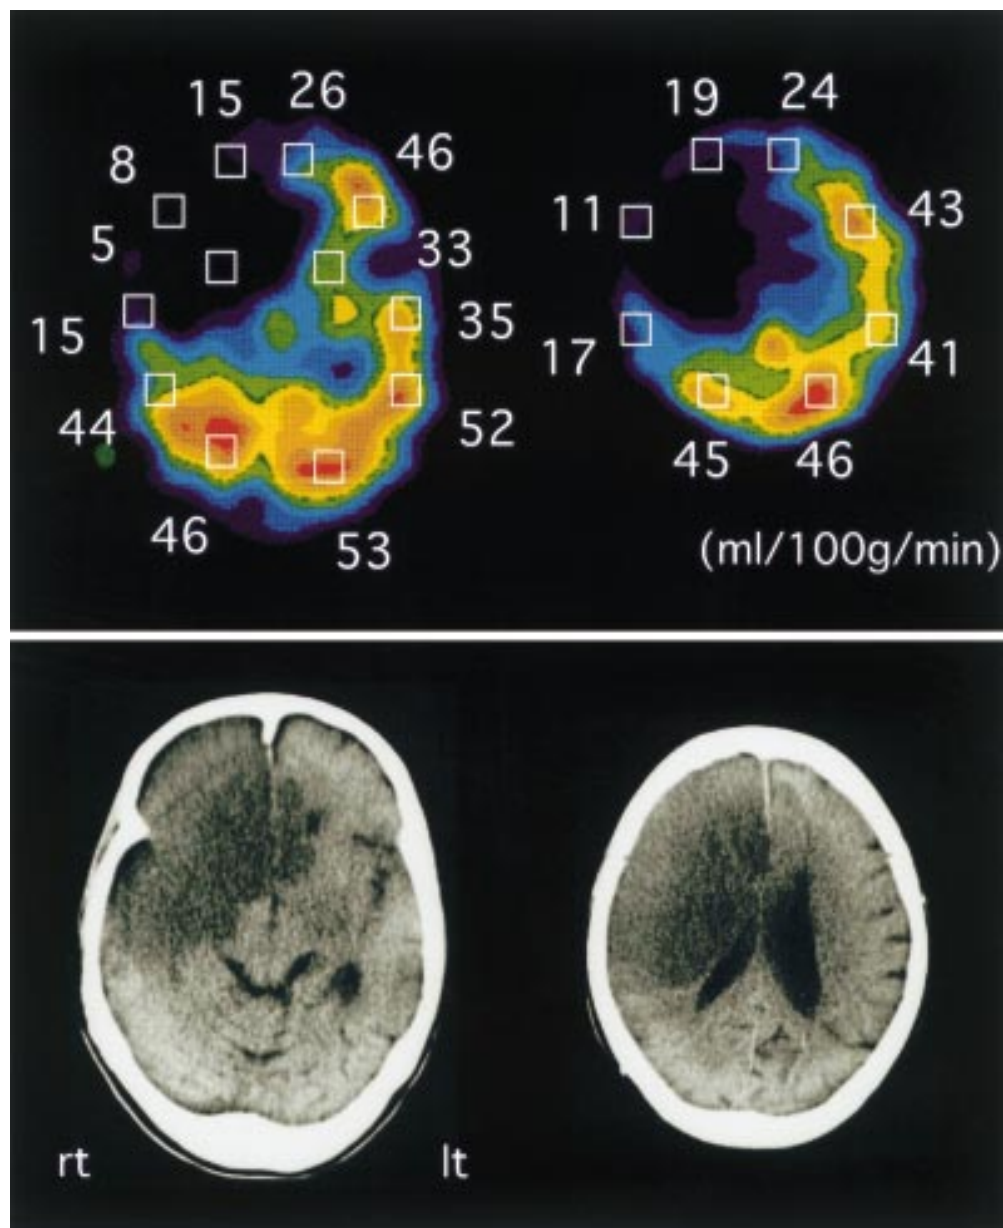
Patient 3. An 88 year old woman became suddenly unresponsive with left hemiplegia. An initial CT showed no abnormal findings but ^{99m}Tc -HMPAO SPECT showed hypoperfusion in the right internal carotid artery (ICA) territory. Regional CBF values in some regions were severely decreased to less than 10 ml/100 g/min (top). Angiography showed complete occlusion of the terminal of the right ICA but she was treated conservatively. Brain CT obtained 2 days after onset showed severe cerebral oedema in the right ICA territory (bottom). Finally she died of cerebral herniation 4 days after the onset.
